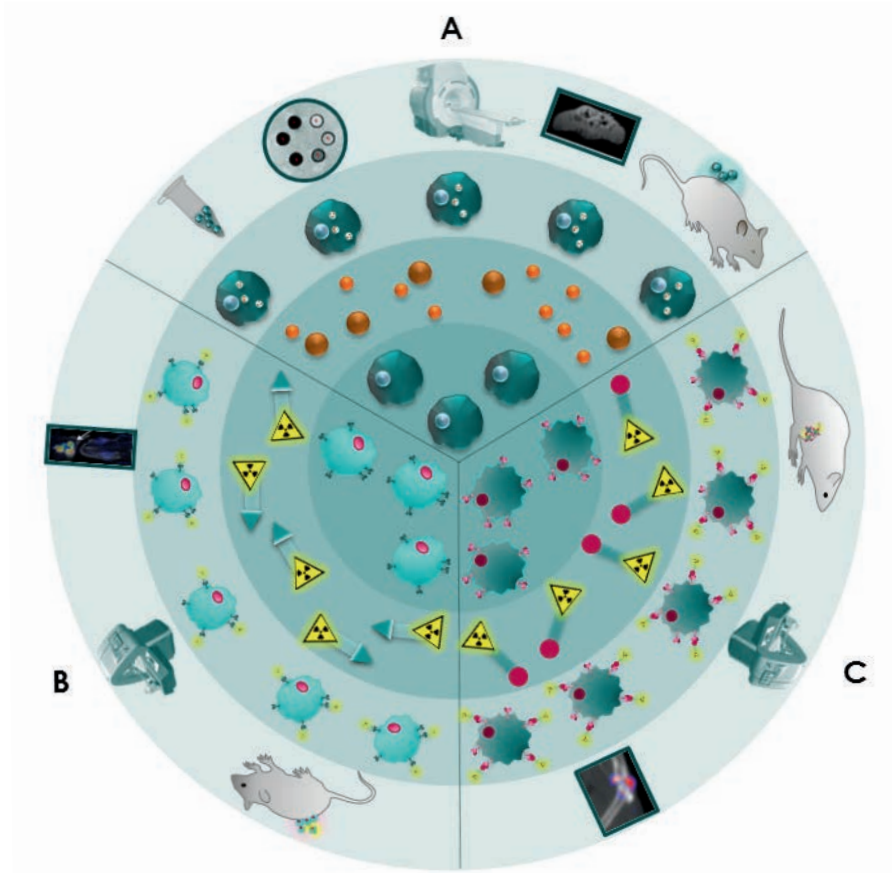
Cellular imaging in A regenerative medicine using iron labelled cells for MRI; B cancer cell imaging for PET or SPECT or therapy using radiolabelled cells; C macrophage imaging during osteoarthritis development using radiolabelled cells for PET or SPECT. Inner ring represents the cell used in research. Second ring shows the label. Third ring displays the labelled cells. Outer ring exhibits the model used with an example of an image obtained with the imaging modality applied.
